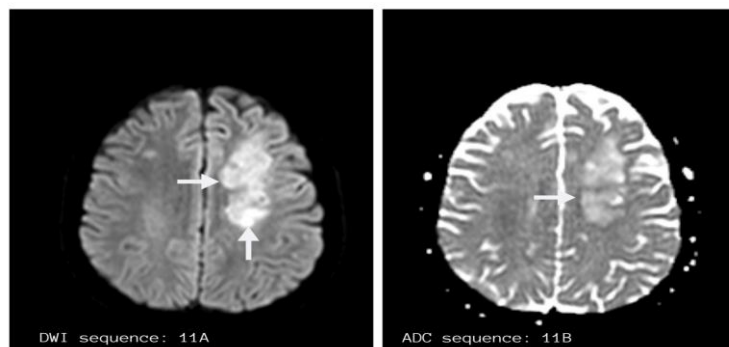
Images showing peripheral patchy diffusion restriction on DWI.
